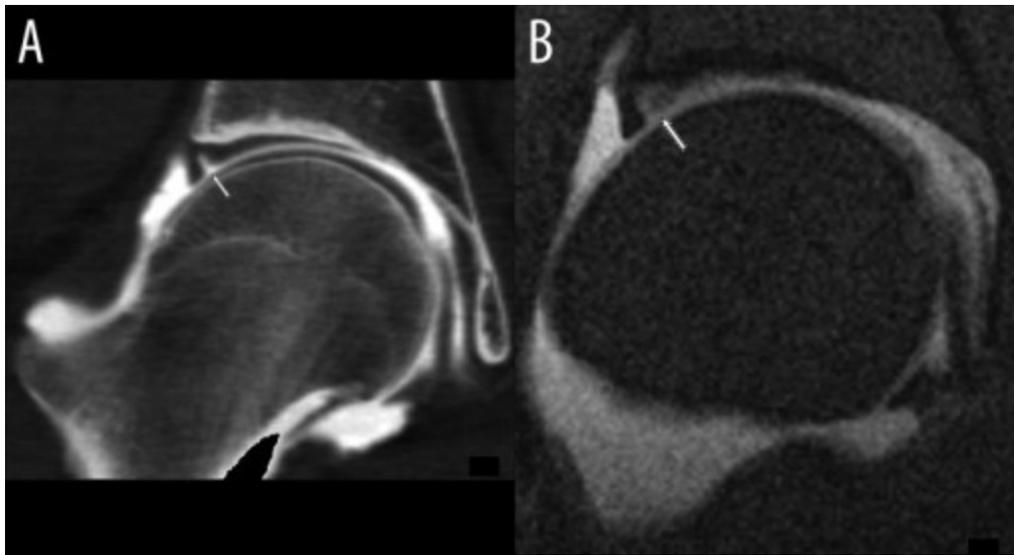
Cam-type femoroacetabular impingement and labral tear in a 36-year-old male with a 4-month history of pain in the right hip. Both coronal reconstruction (A) and corresponding T1-weighted fat-saturated MRA (B) show contrast extension into the anterosuperior labrum compatible with a tear (arrows). (Source: Sahin M, Calisir C, Omeroglu H, Inan U, Mutlu F, Kaya T. Evaluation of Labral Pathology and Hip Articular Cartilage in Patients with Femoroacetabular Impingement (FAI): Comparison of Multidetector CT Arthrography and MR Arthrography. *Pol J Radiol.* 2014 Oct 24;79:374-80.)
